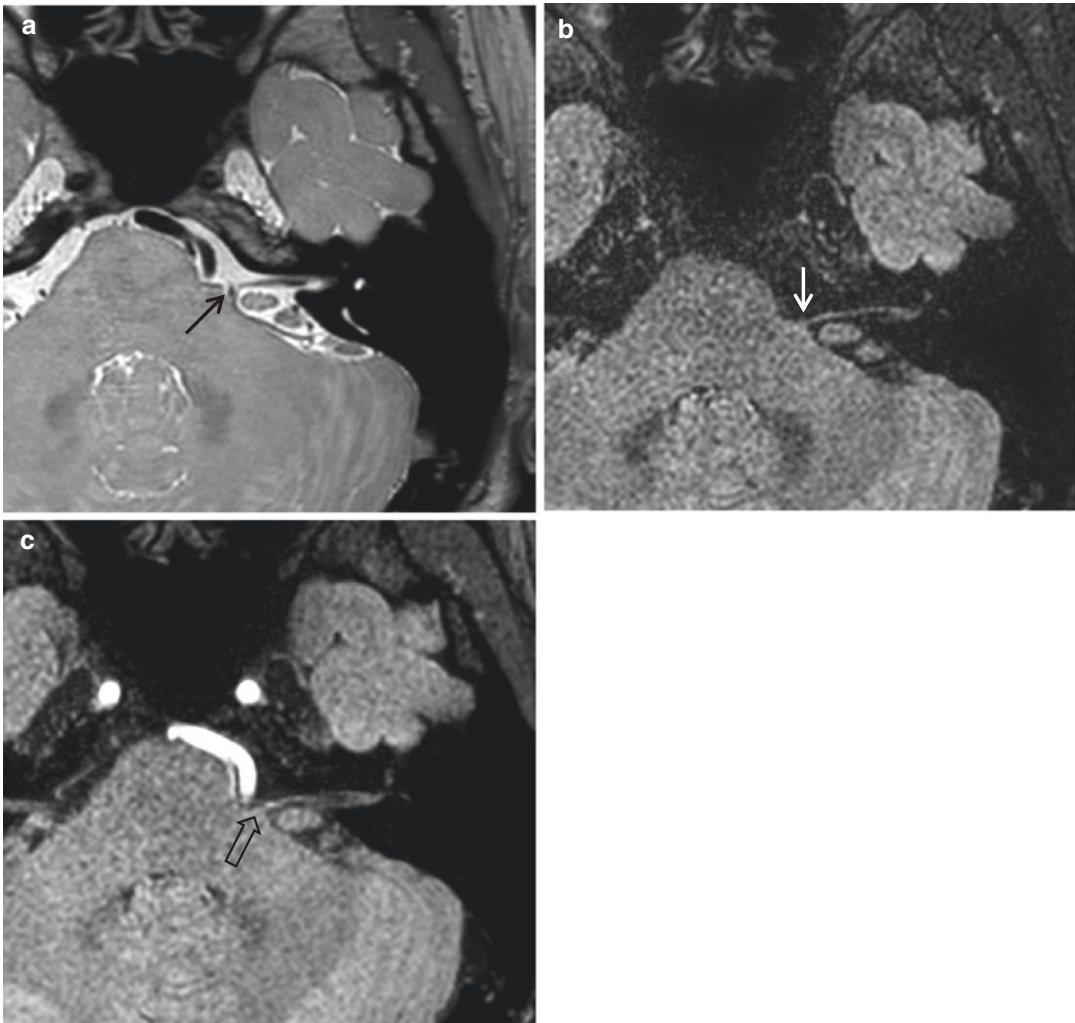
Usefulness of 3D FLAIR for better demonstration of the proximal course of the facial nerve. (a) On MRC, the proximal portion of the facial nerve overlaps with the vascular structure, making it difficult to trace (arrow). (b) On 3D FLAIR, the proximal portion of the facial nerve
